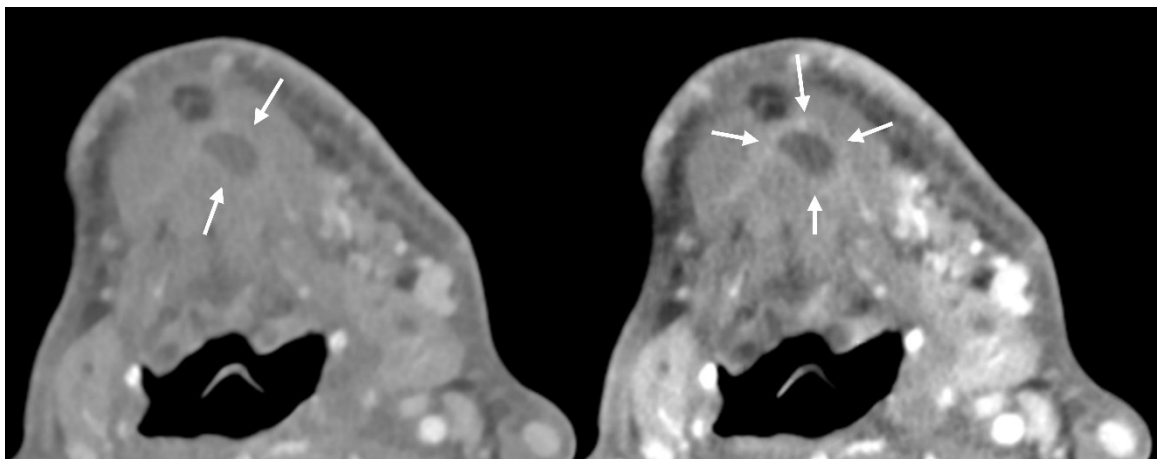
76-year-old male with a sublingual abscess. The 70 keV virtual monochromatic image (A), which approximates conventional CT, shows a low density area with a rim-like
